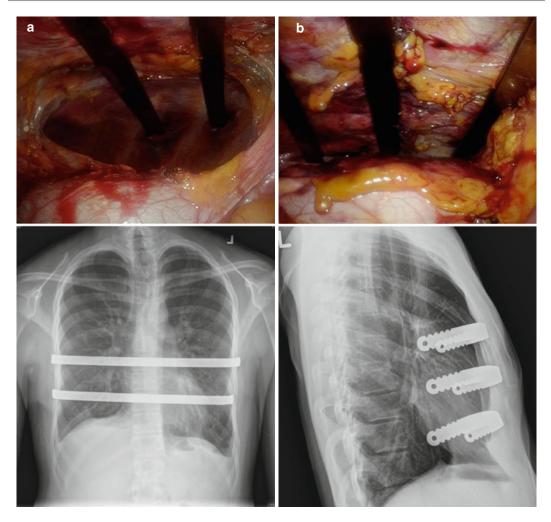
(a, b) Intraoperative photograph and chest roentgenograms showing the placement of 2 and 3 Nuss support bars for repair of pectus excavatum deformity
